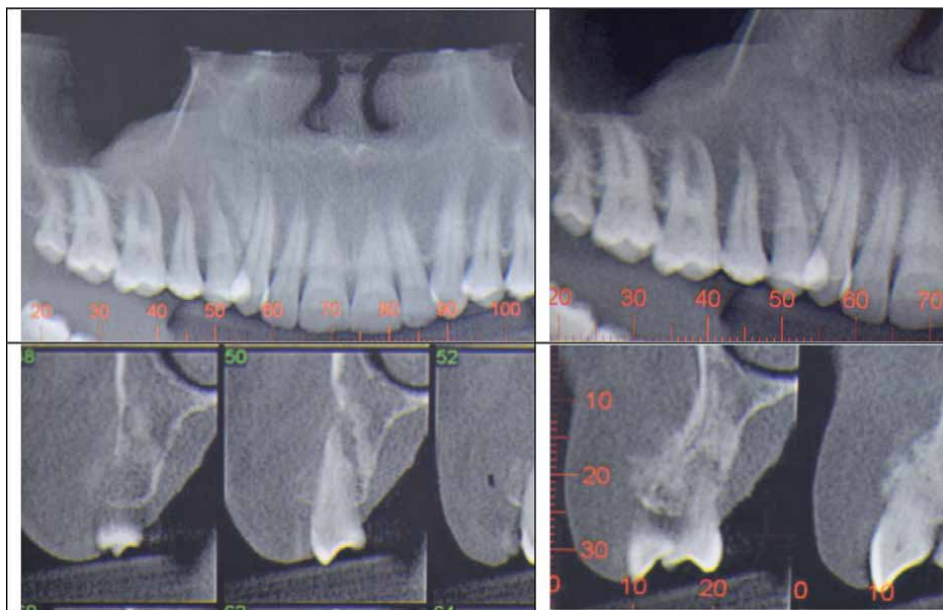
Radiographic imaging of patient showed in Figure 1, a 35-year-old female with a maxillary osteosarcoma.
